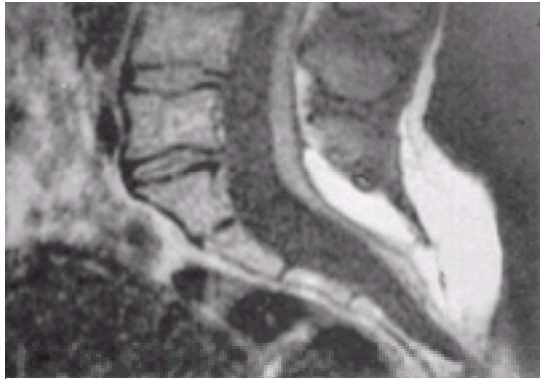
Mid-sagittal magnetic resonance image of lipomeningocele with elongated tethered filum terminale. Lipomatous structure extends into subcutaneous space.
